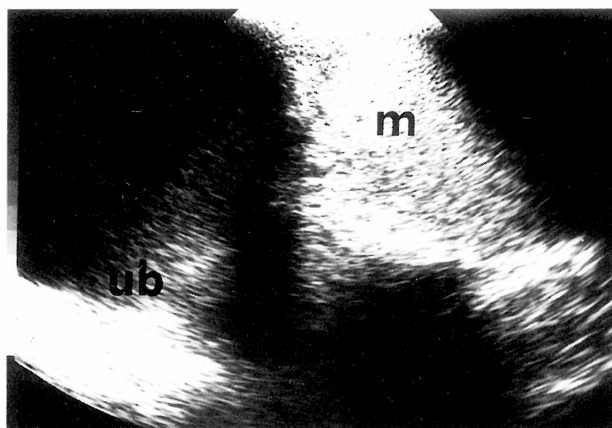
Ultrasound (longitudinal view). Large echogenic mass elevating the urine bladder.
